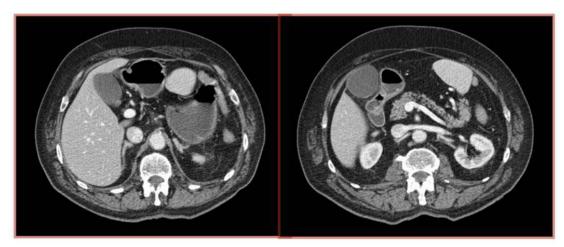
Enhanced CT scan shows the spleen in an unusual topography, posterior to the anterior abdominal wall, to the left of the midline and superiorly bounded by the gastric wall.
